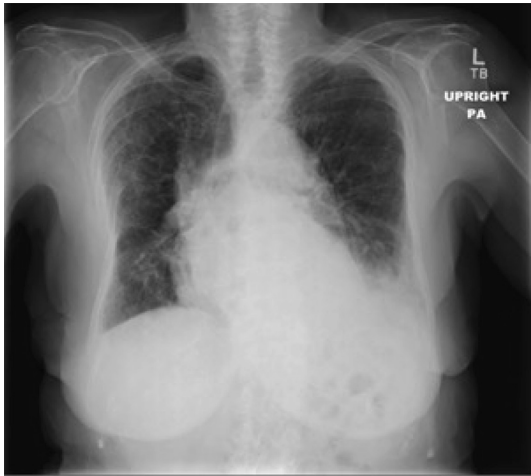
Plain radiography in the upright position showed a slightly enlarged heart size with a parenchymal opacity visualized in the left lower lobe, which partially silhouetted the left hemidiaphragm and obscured the cardiac apex.
